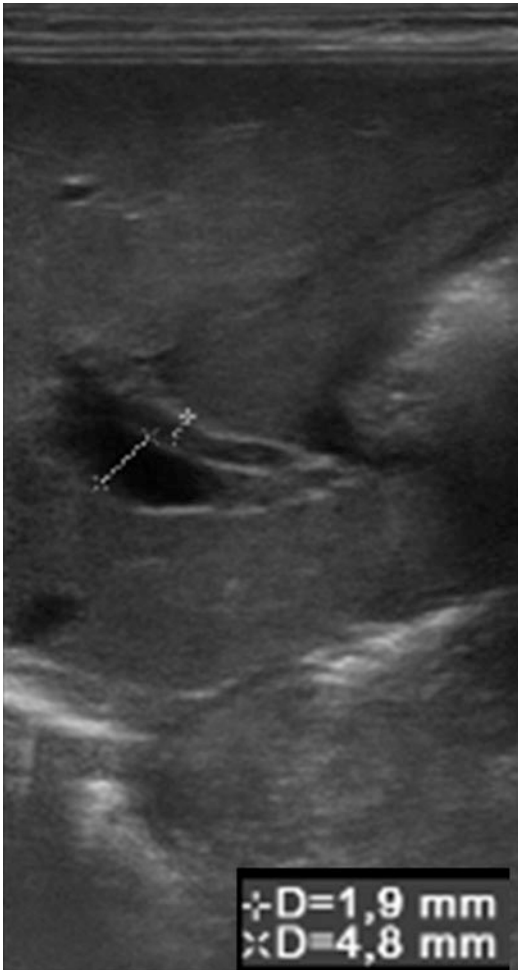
High-frequency sonographic scan shows an enlargement of the hepatic artery diameter (>1.5 mm at the level of proximal right hepatic artery). This sign, combined with other US findings, can be highly suggestive of BA. The hepatic artery and portal vein are easily detectable structures in the porta hepatis as shown in this figure. In BA the ratio HA/PV is higher because of artery hypertrophy
